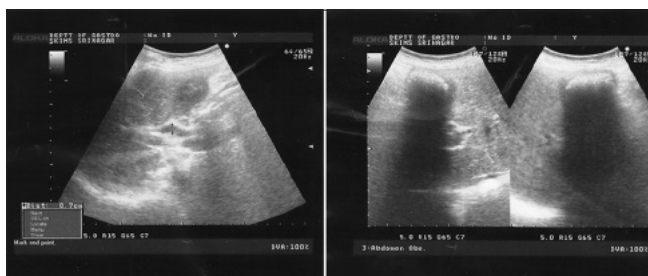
Ultrasonography revealing bulky pancreas
